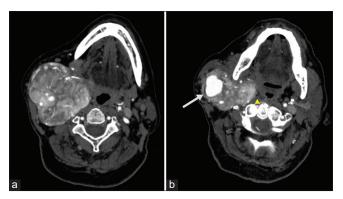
Axial computed tomography angiography of the neck (a,b) demonstrates a large, enhancing, hypervascular, lobulated mass originating in the carotid space, encasing the common carotid and internal carotid arteries, and extending into the masticator and parotid spaces. This mass causes obliteration of the right parapharyngeal fat pad (arrowhead, b). A large contrast-filled collection measuring up to 3.5 cm is noted within the tumoral mass (arrow, b), consistent with a carotid body tumor with an intratumoral pseudoaneurysm.
